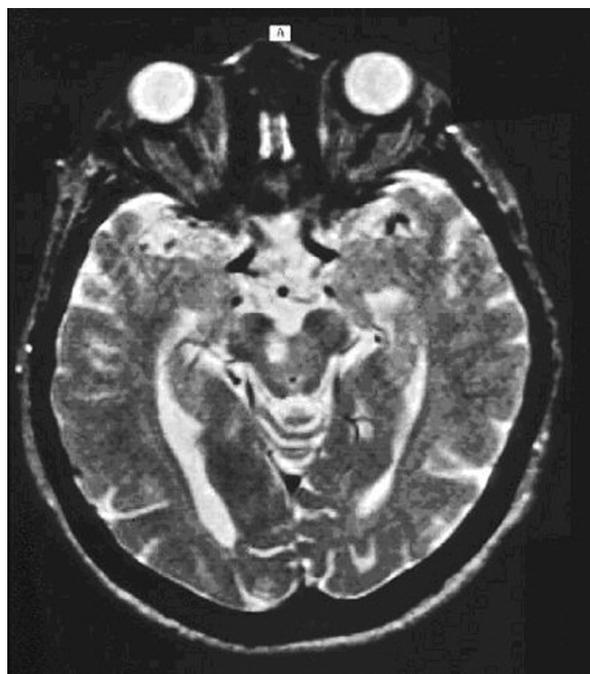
An ischemic lesion in the region of the red nucleus (MRI T2-weighted images).
